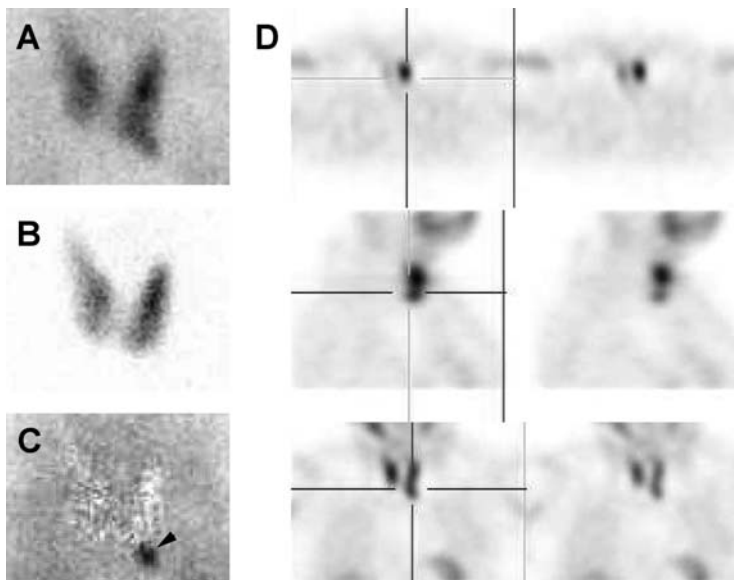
Planar pinhole (A: ^{99m}Tc -sestamibi, B: ^{123}I , C: subtraction images) and SPECT images (D) of parathyroid adenomas. Typical P3 adenoma which is located at the tip of the left inferior lobe on planar images and remains anterior on SPECT images.
